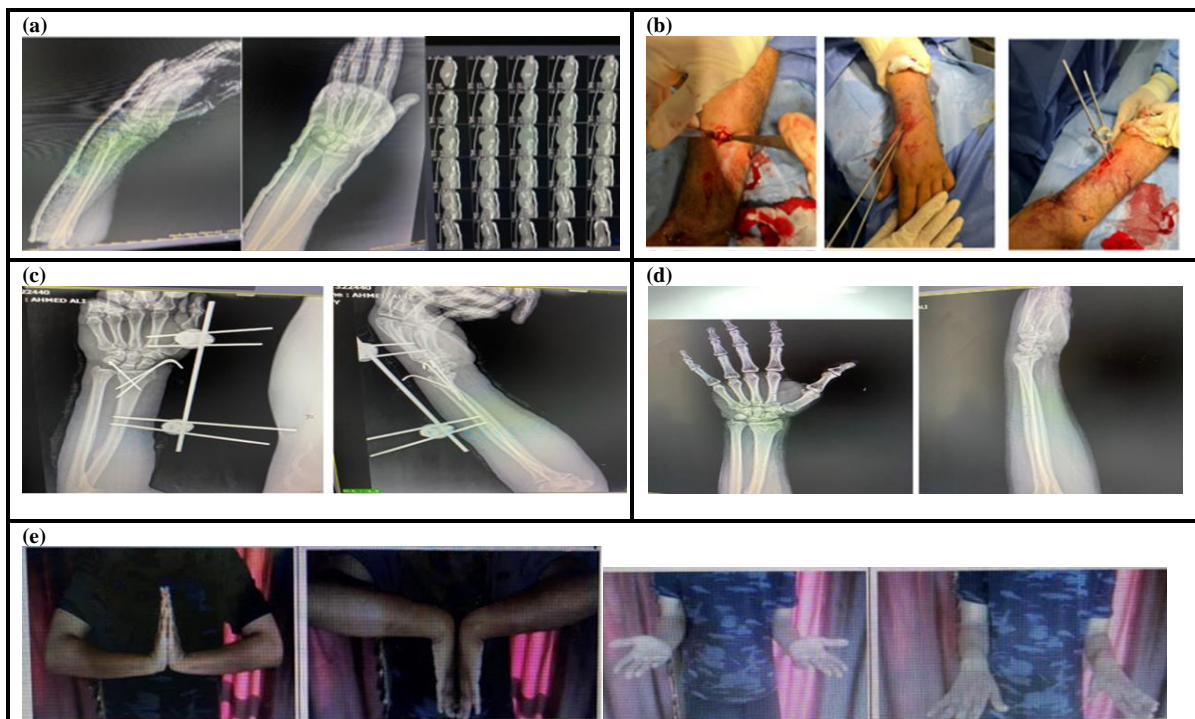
A 46 years male patient with left non dominant comminuted distal radius fracture for external fixator and k-wires; (a) preoperative x-ray and CT; (b) intraoperative photos; (c) 1 week postoperative; (d) 6 months post-operative; and (e) post-operative ROM.
